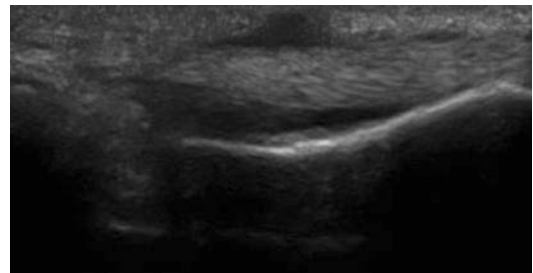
Sonography under provocation, massive bowstringing over the A2 pulley
